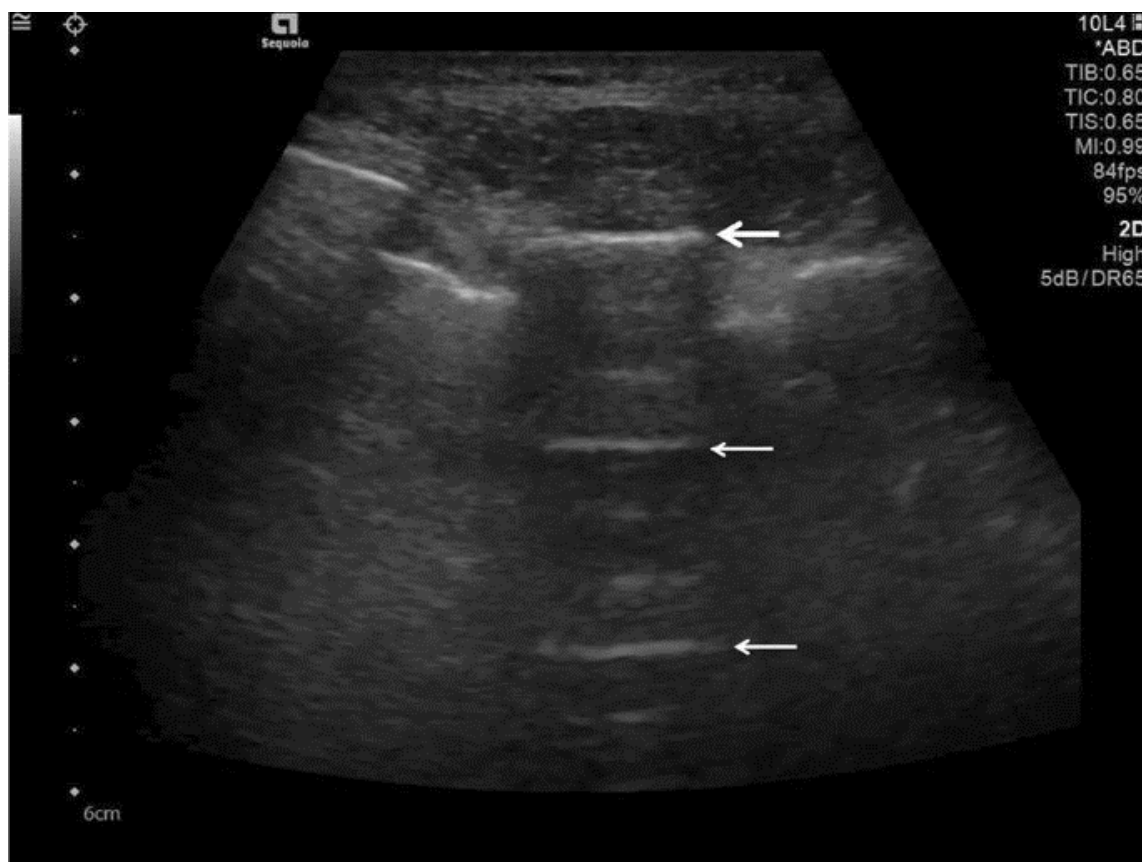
Ultrasonography detected A-lines using an abdominal probe. A-lines (white arrows) appears as bright horizontal lines deep to the pleural line (bold white arrow).
